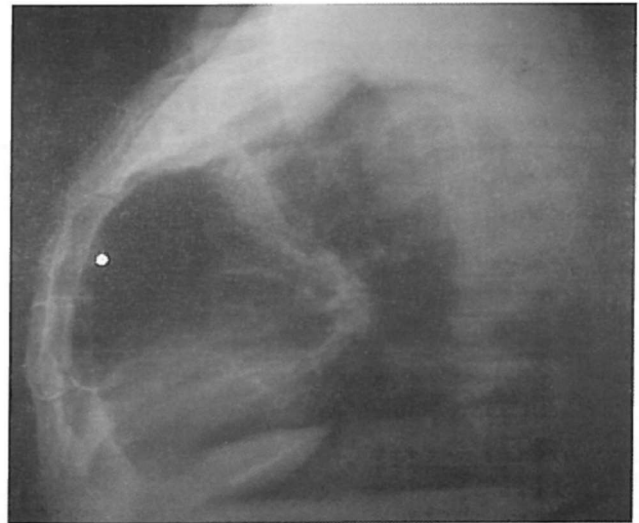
Right lateral chest x-ray showing reduced retrosternal space superiorly by the dilated aorta as well as thoracic spondylotic changes.
